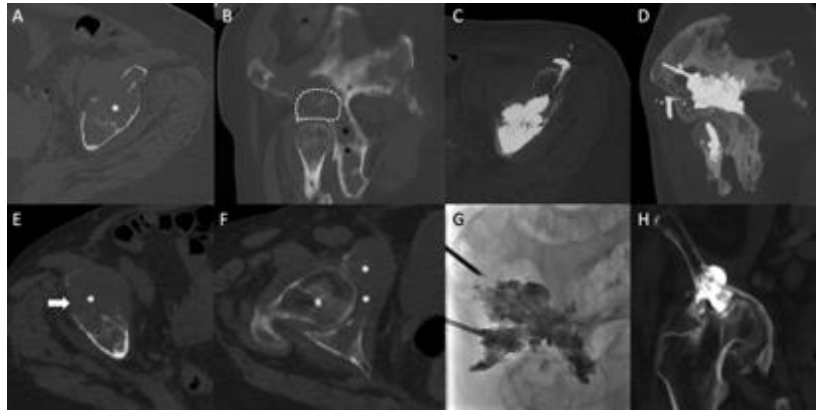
Cementoplasty for extensive supra-acetabular osteolysis. (A) Axial CT- scan shows a large amount of osteolysis and destruction of the acetabular roof with minimal cortical integrity (asterisk). (B) Sagittal oblique view shows a diffuse extension of the lesion. The roof of the acetabulum (dotted line) is at high risk of mechanical failure, while the posterior part (black asterisk) has very limited weight-bearing function. (C) And (D) The roof was filled as much as possible with cement while the posterior part was left untreated. Small asymptomatic anterior leakage in the soft tissue. (E) Axial CT-scan in another patient demonstrating a large supra-acetabular osteolytic lesion (asterisk) with destruction of the lateral cortex (arrow). (F) Axial CT-scan more caudally shows that the medial wall of the acetabulum (asterisks) is also completely destroyed. (G) Large volume cementoplasty was performed as the patient was not a surgical candidate due to other comorbidities. (H) One-year follow-up shows recalcification under systemic treatment. However, there is a complete destruction of the hip joint due with acetabular protrusion.
